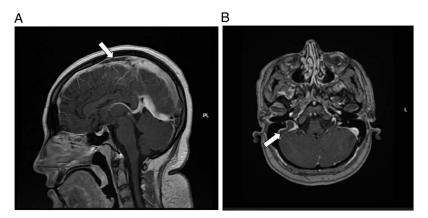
MRI of the brain with contrast: (A) sagittal view showing a thrombus in the superior sagittal sinus (arrow). (B) Axial view showing a thrombus in the right sigmoid sinus (arrow).
